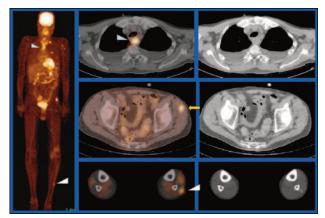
"True" whole-body PET/CT, scanning from the top of the patient's head to the soles of the feet, revealed soft tissue metastases outside the conventional field of view (base of the skull to the upper thigh) in 78% of patients in this study. This patient was found to have a metastatic lesion in the lower leg.
